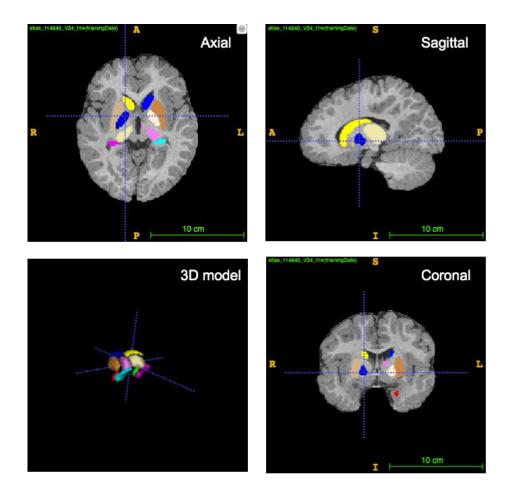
MRI scan images of 12-24 months old infants.
